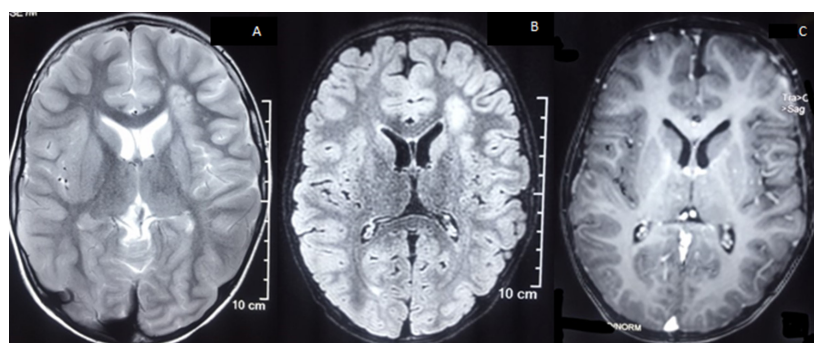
MRI of the brain. (A) T2-weighted and (B) fluid-attenuated inversion recovery axial scans showing subacute infarct involving left frontal cortex, anterior limb of internal capsule, left caudate head and putamen. (C) T1-weighted post-gadolinium axial images showing patchy contrast enhancement.
